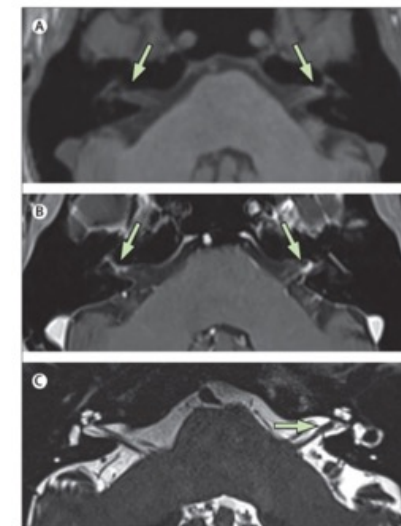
Focal nodular thickening and contrast enhancement of facial nerve on brain MRI
